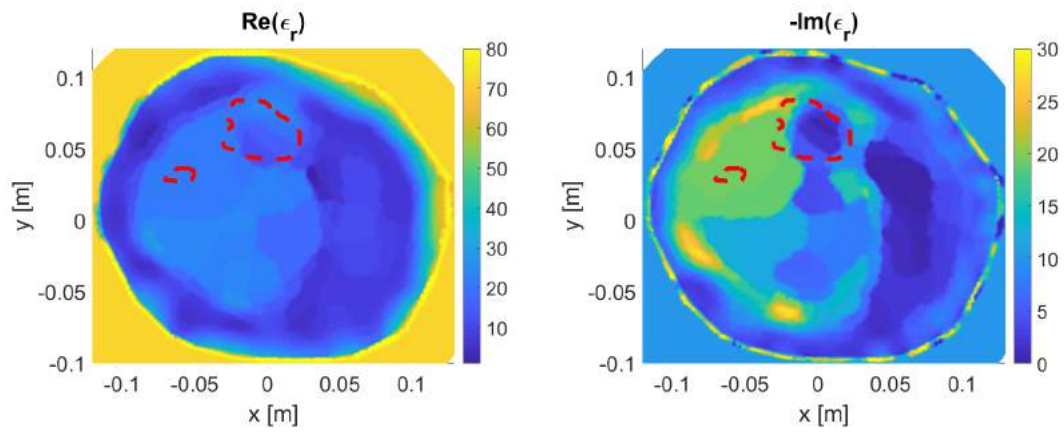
Inversion results for the imaginary-part clustering model using the ultrasound gel with mid-value inhomogeneous scenario.
